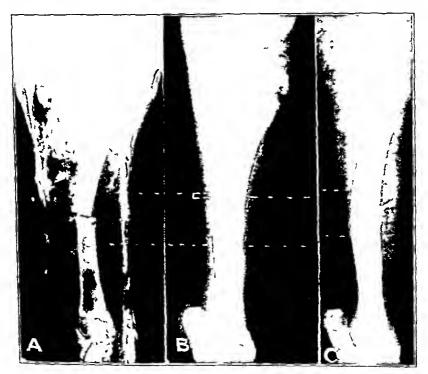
Bisected tibia with a full thickness segment of epiphysial cartilage interposed between the parts. The intervening periosteum was removed. The cut ends of the tibia were marked with steel shot placed in drill holes in the cortex. A, roentgenogram taken immediately after operation, B, roentgenogram taken three weeks after operation. C roentgenogram taken three months after operation. Note the extent of repair in three weeks, the progressive replacement of transplanted epiphysial cartilage by bone and the progressive lengthening of the bone. Note the slight shortening which took place during the first three weeks and that therefore the shot remained equidistant. None of the growth in length, therefore was acquired at the site of section from either the transplanted growth cartilage or the process of repair of the bisection. All growth took place at the epiphysial ends of the shaft, the major portion at the proximal end.
